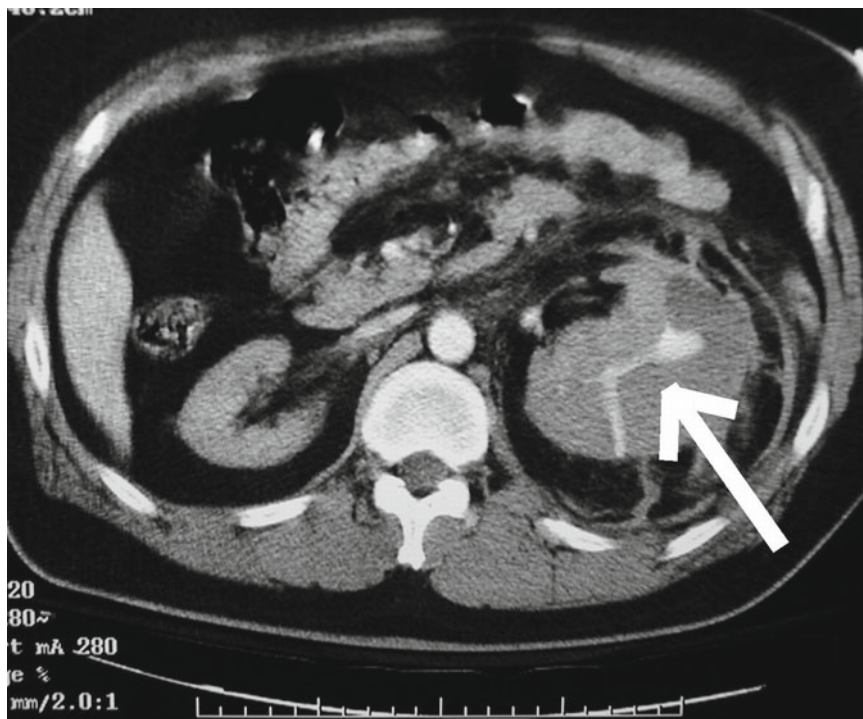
CT scan showing renal arteriovenous malformation (AVM) secondary to renal biopsy
